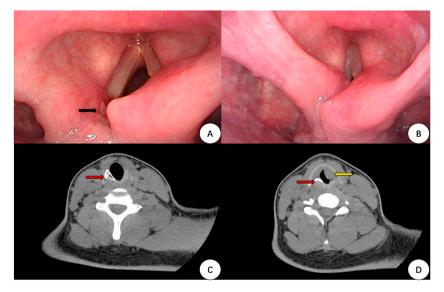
Laryngoscopy and CT of the larynx.
